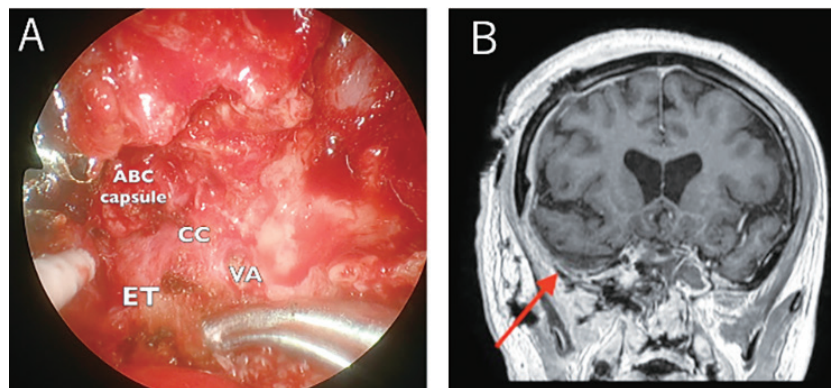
A; Operative view of resecting ABC capsule in the right infratemporal fossa CC; carotid canal, ET; eustachian tube, VA; vidian artery. B; MRI with contrast enhancement after the secondary surgery. There is no recurrence of the ABCs in the temporal fossa (arrow).
